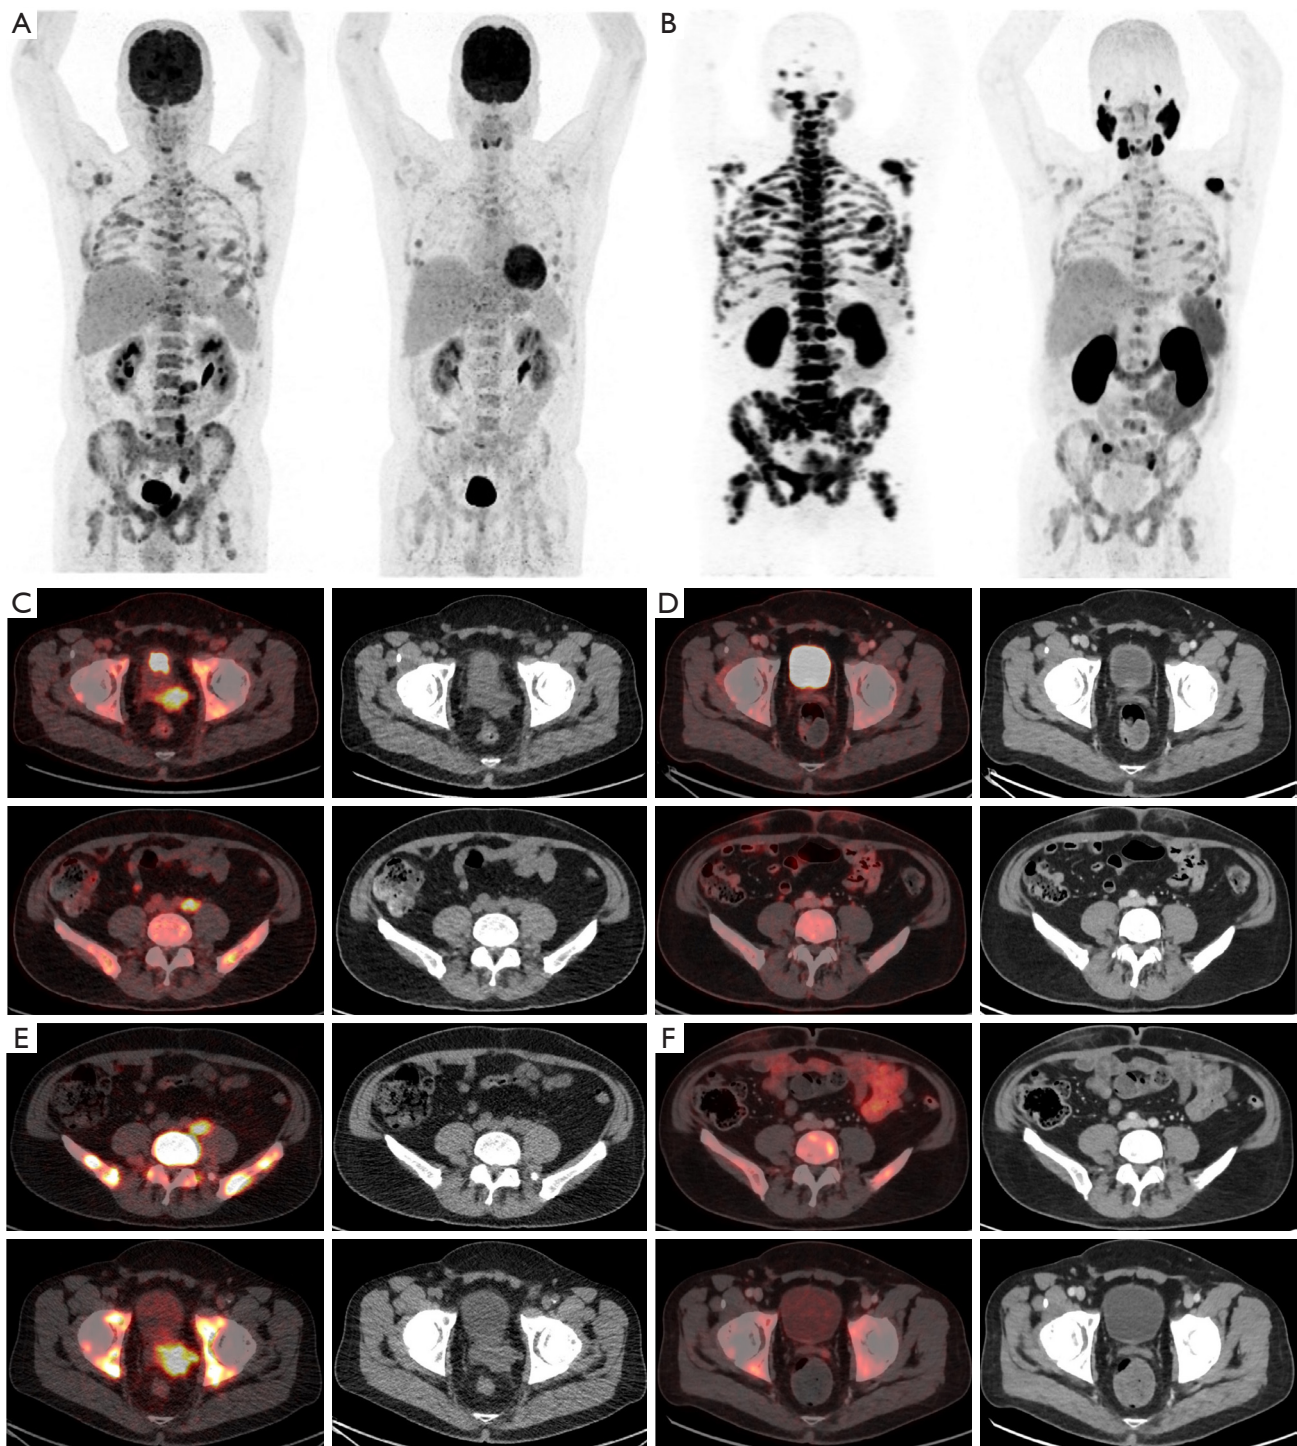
Imaging results at diagnosis and through the course of treatment. FDG PET-CT (A) and PSMA PET-CT (B) whole-body scans showing the comparison of the metabolically active metastases before (on the left) and after 6 cycles of chemotherapy with an addition of GnRH antagonist (on the right). FDG PET-CT (C,D) and PSMA PET-CT (E,F) scans with concomitant CT scans: at the diagnosis (C,E) and re-staging after 6 cycles of chemotherapy with etoposide/carboplatin with an addition of GnRH antagonist (D,F). FDG PET-CT, fluorodeoxyglucose positron emission tomography-computed tomography; PSMA, prostate-specific membrane antigen; GnRH, gonadotrophin-releasing hormone.
